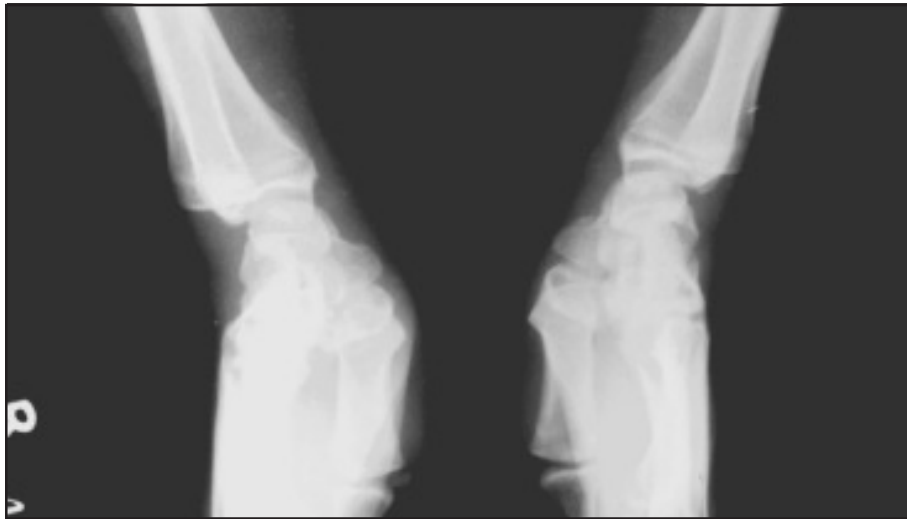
Xray lateral view showing bilateral scaphoid
